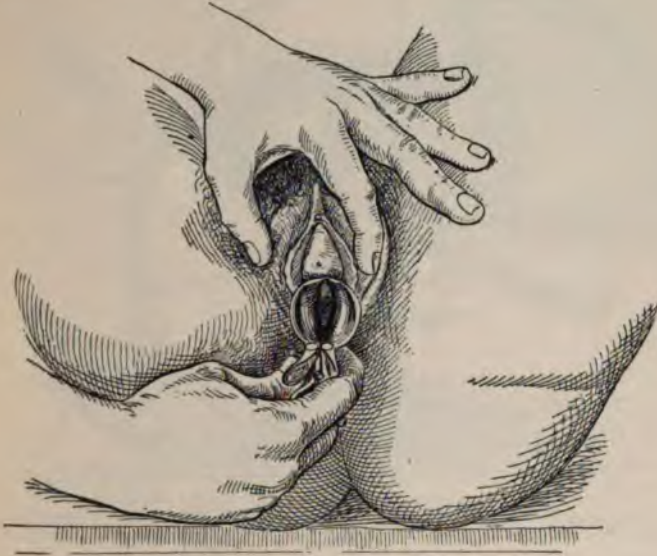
INDIRECT INSPECTION OF THE VAGINA.
